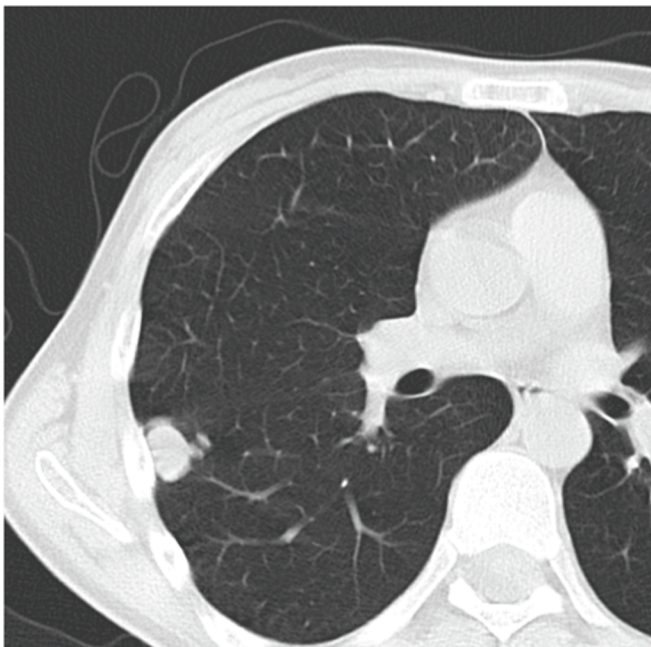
Initial computed tomography finding of the lung. Computed tomography revealed a 2-cm-sized nodule in the right lower lobe of the lung.
